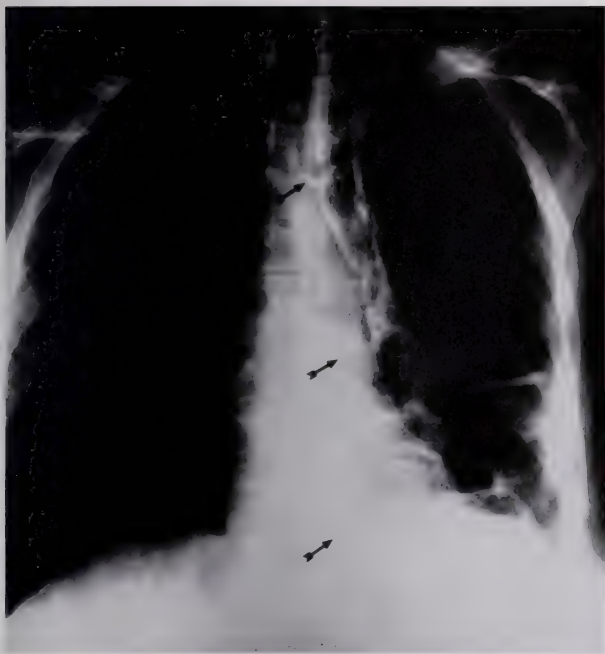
Roentgenogram of a patient with a segment of left colon utilized for esophageal replacement. Arrows point to the colon containing barium.
